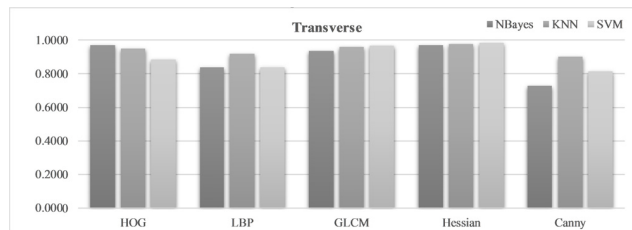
Comparison of five feature extraction algorithms on the transverse ultrasonograms.
